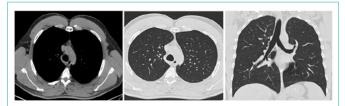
A regular lung pattern is shown at CT. A thymic gland in the anterior mediastinum is seen.
